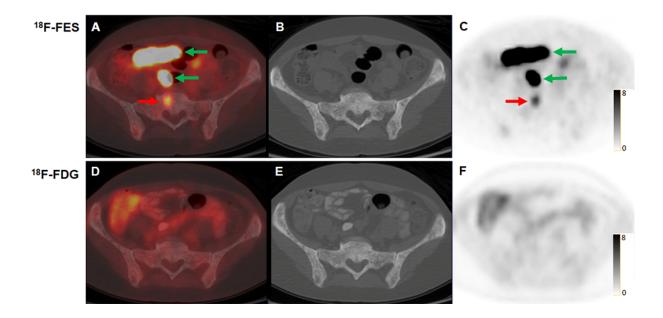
Metastatic disease apparent on ¹⁸F-FES PET but not on ¹⁸F-FDG PET in a 48-year-old woman with biopsy-proven metastatic ILC (patient 5). Axial fused ¹⁸F-FES PET/CT (A), CT (B), and ¹⁸F-FES PET (C) demonstrates ¹⁸F-FES-avid osseous foci (red arrow), consistent with avid malignancy. Physiologic activity was also seen in the bowel (green arrows). Axial fused ¹⁸F-FDG PET/CT (D), CT (E), and ¹⁸F-FDG PET (F) did not demonstrate any FDG-avid foci suspicious for malignancy.
